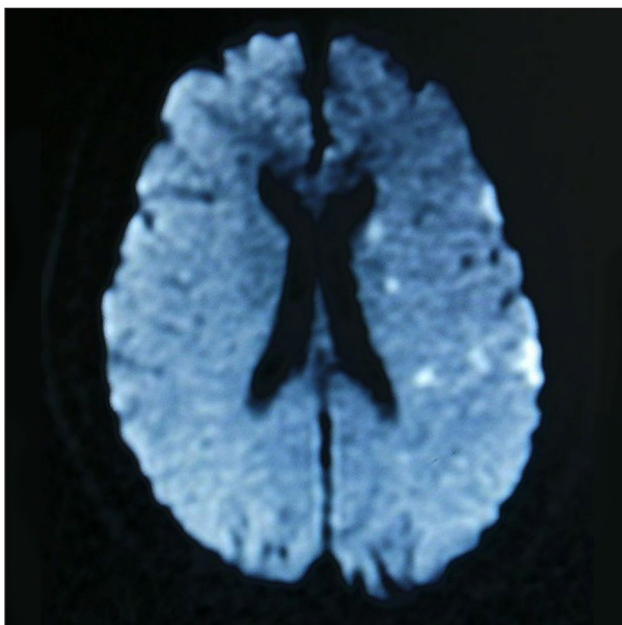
Diffusion weighted magnetic resonance imaging on July 22 2009, demonstrating multiple recent infarcts in the territory of the left middle cerebral artery
